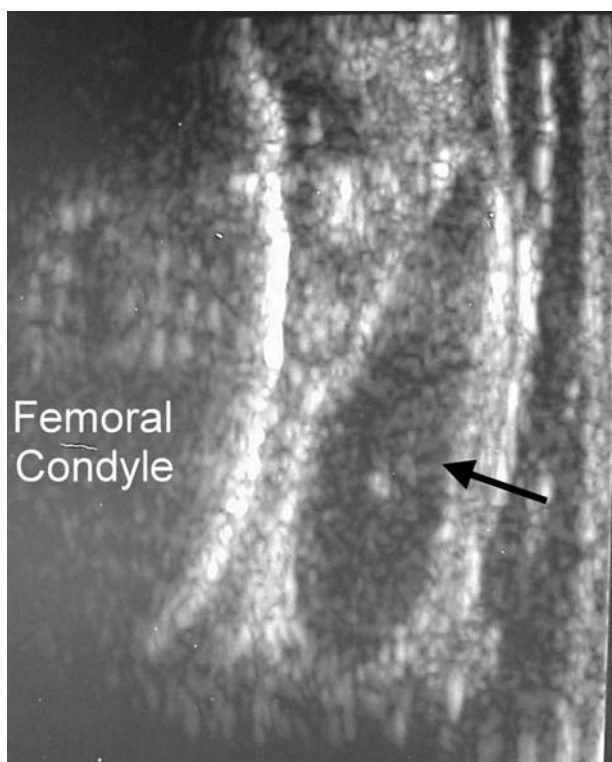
Coronal plane ultrasound of the lateral femoral condyle. The arrowed structure has deep acoustic enhancement suggesting a ganglion cyst, but internal echoes suggest a solid structure. Colour Doppler showed internal blood flow in this synovial sarcoma.
